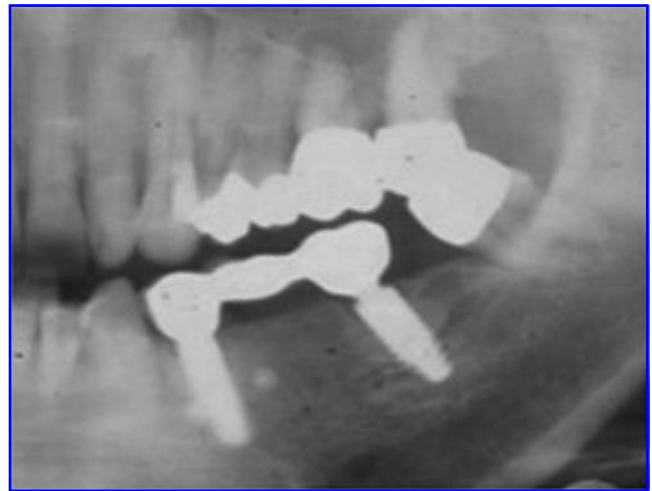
Radiographic examination 3 y after loading showing excellent formation of new calcified (bone-like) tissue.
